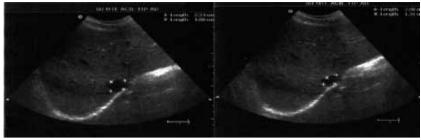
Axial cross-section ultrasound of the inferior vena cava during expiration and inspiration showing measurements.
